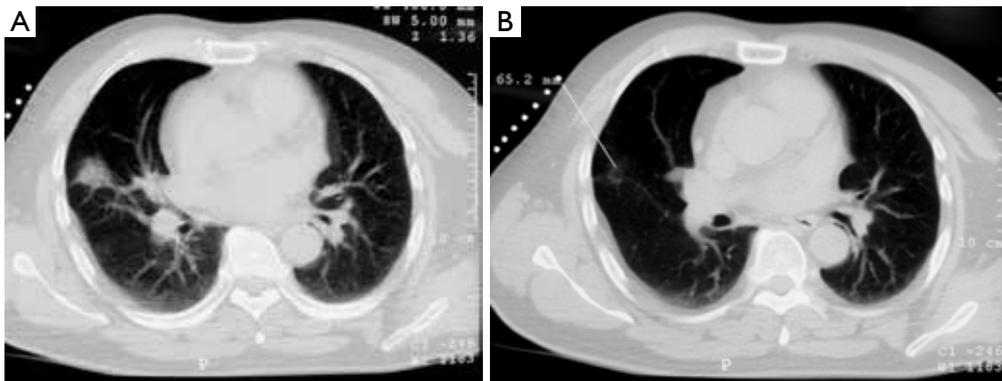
Chest CT shows: (A) a soft tissue density (1.5 cm × 1.5 cm) with irregular margin in the right middle lobe; (B) angle and depth of puncture.
